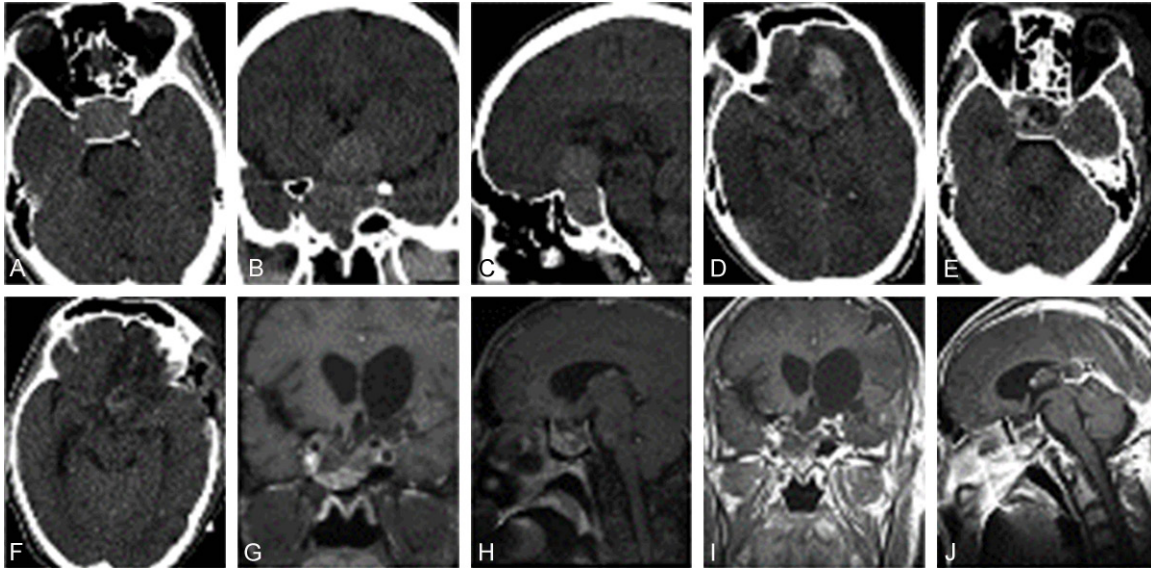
Imaging manifestations of case No. 6. (A) Axial (B) coronal and (C) sagittal computed tomography (CT) non-contrast enhanced scanning before admission to hospital. (D) Axial CT on the patient with aggravated condition on the second day after admission. (E and F) CT on the second day after craniotomy. (G) Coronal and (H) sagittal enhanced MRI scans before secondary transsphenoidal surgery. (I) Coronal and (J) sagittal enhanced MRI scans four months after transsphenoidal surgery. MRI, magnetic resonance imaging.
